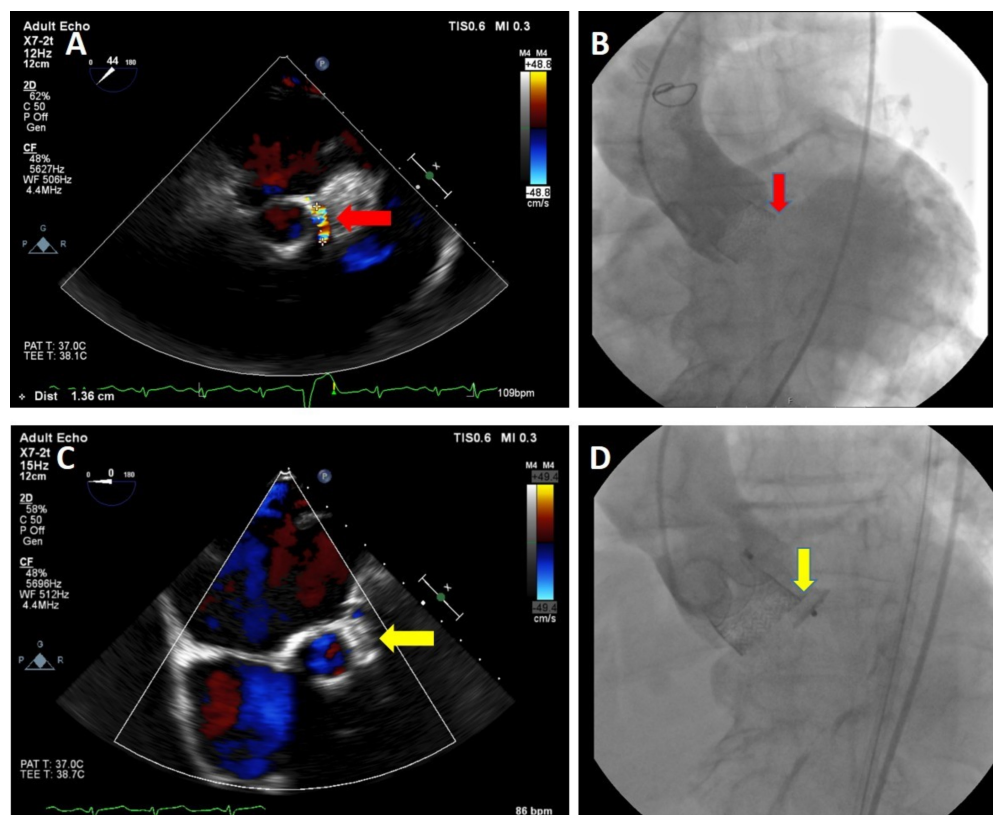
Patient 1. (A) Transesophageal echocardiography, short-axis view, demonstrating severe paravalvular regurgitation adjacent to a 19-mm Edwards Intuity valve. (B) Baseline aortography confirming severe paravalvular leak. (C) Fluoroscopy showing a 10 × 5-mm Amplatzer Vascular Plug III deployed within the paravalvular defect. (D) Post-deployment aortography demonstrating complete resolution of the paravalvular leak.
